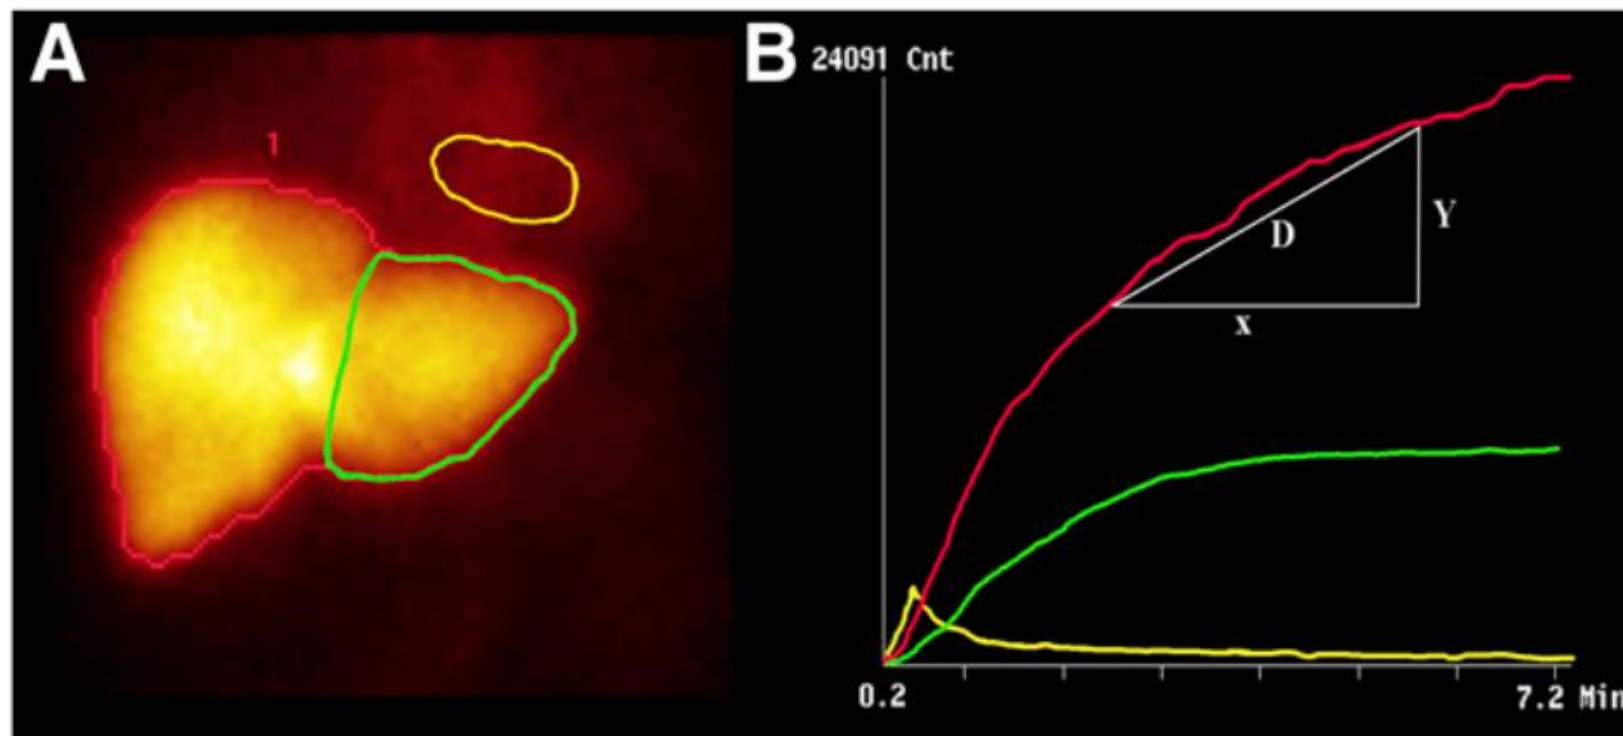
Quantitative hepatobiliary scintigraphy in three showing normal hepatocyte extraction fraction (HEF) and $T_{1/2}$ excretion. (Courtesy of Dr Eva Dubovsky.)
